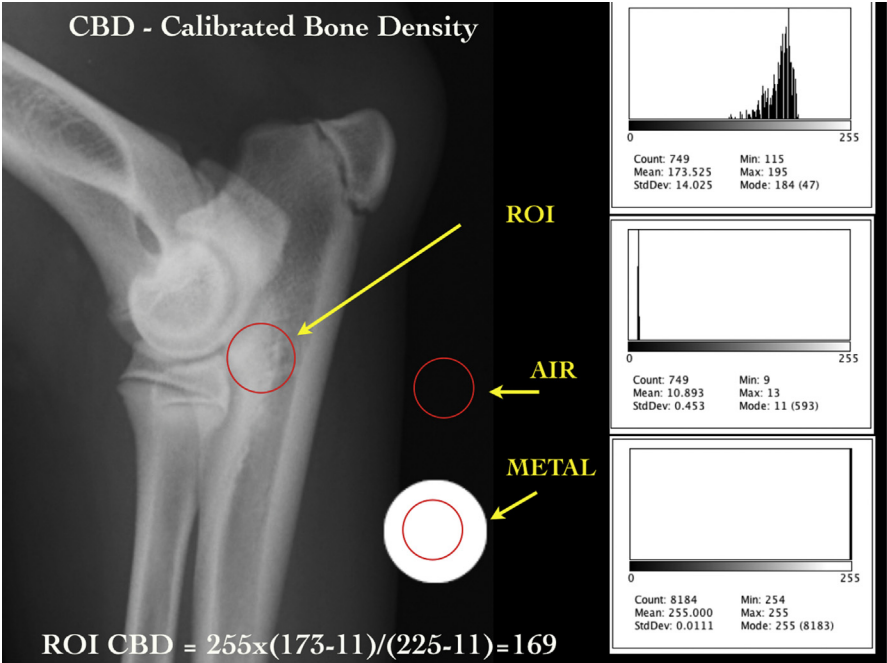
Radiographic STS can be evaluated both visually and with objective measurement with digital assessment of calibrated bone mineral density using computer applications like the public domain application Image J. ROI, region of interest.
